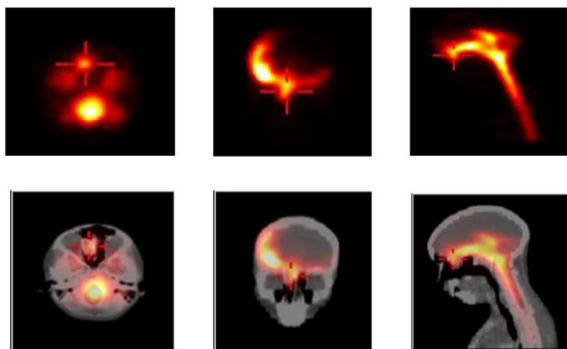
Planar Images Show Focal Uptake in the Frontal Skull, Localized by SPECT/CT to the Right Ethmoid Bone.
